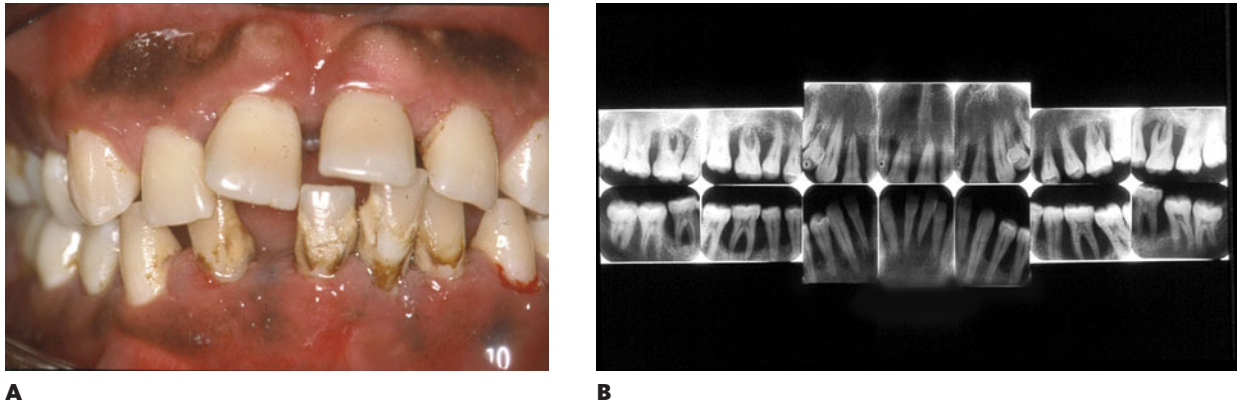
Clinical (A) and radiographic (B) presentation of a 16-year-old patient with aggressive periodontitis. Note that the severity of bone loss extends to the apex at several teeth. doi:10.1128/9781555818906.ch13.f2
